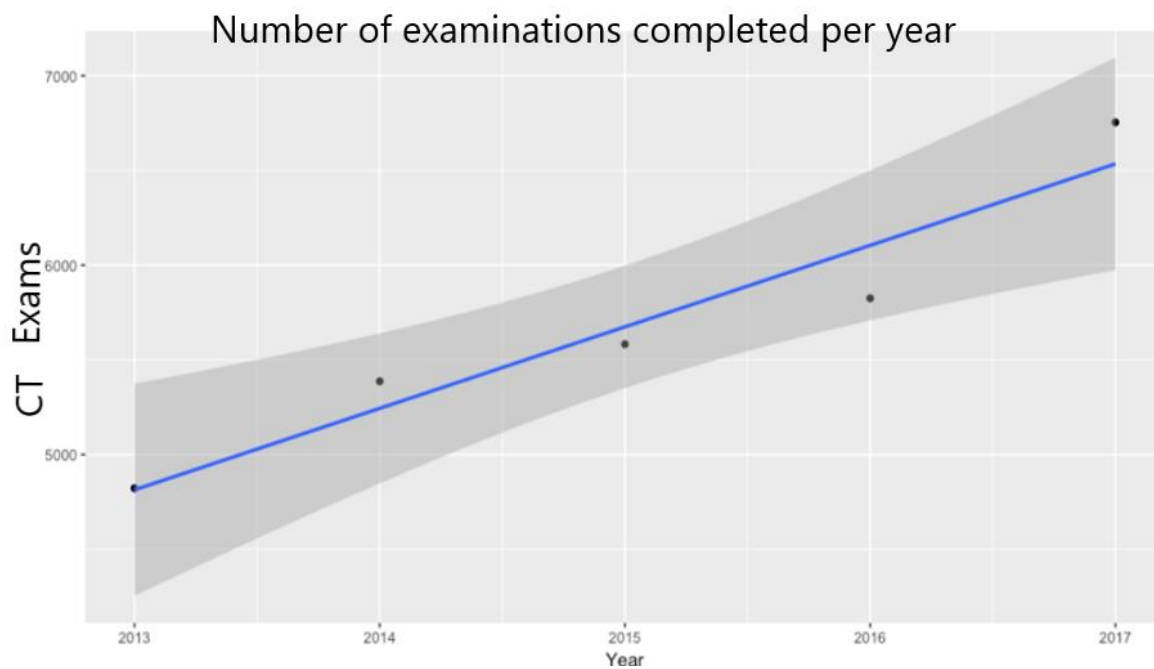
Increase in yearly demand for CT
